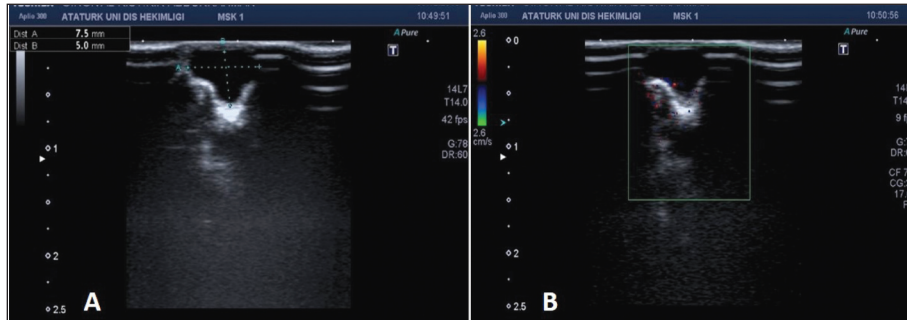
Intraoral ultrasonography scanning of the lesion. A: The homogeneity, anechoic, cystic lesion with posterior acoustic enhancement. B: The lesion showed no central blood supply and blood vessel in the color Doppler ultrasonography.
